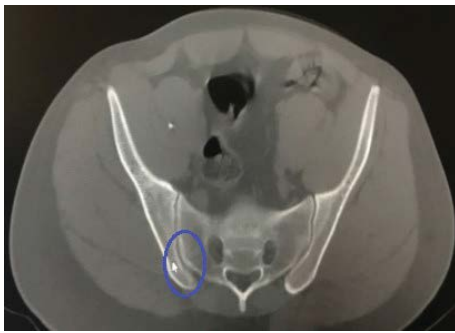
Unilateral axial computed tomography section image of the crescent like iliac bony plate variation at the S2 vertebral level in a 26-year-old man patient.
